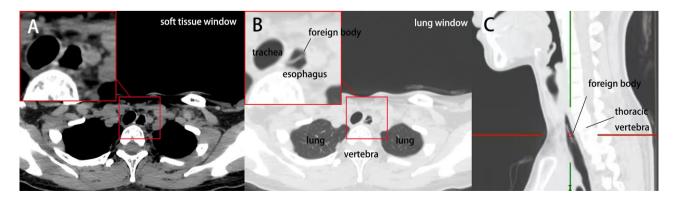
CT images of esophageal foreign body. (A) Transverse section on T2 level in soft tissue window; (B) Transverse section on T2 level in lung window; (C) Sagittal section of esophagus and foreign body in lung window
